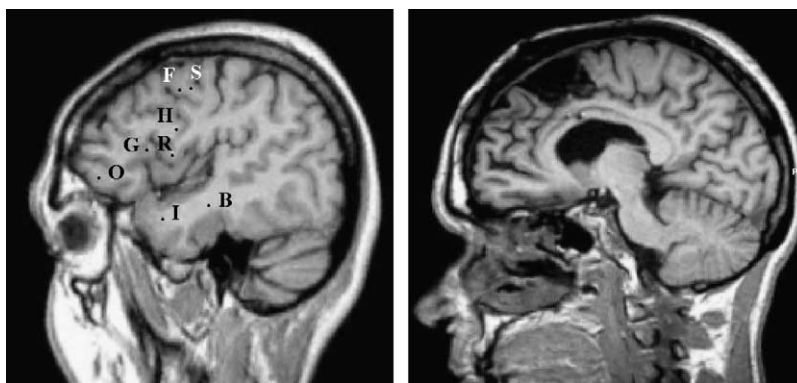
Left side:* Electrodes implanted in the right fronto-temporal region of patient 1. Note that electrode S and F were located in right SMA-proper and pre-SMA, respectively. *Right side:* Post-operative MRI showing the area of resection in the same patient.
